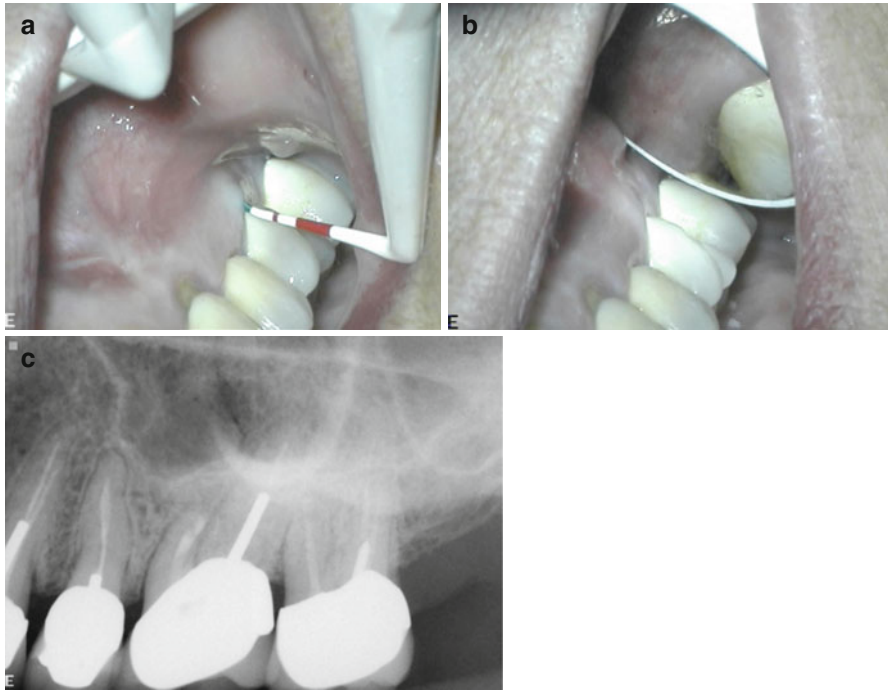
Continuation of case in Figs. 3.12 and 3.13. (a, b) are clinical images of soft tissue healing after 1-year recall. (c) One-year recall radiograph
